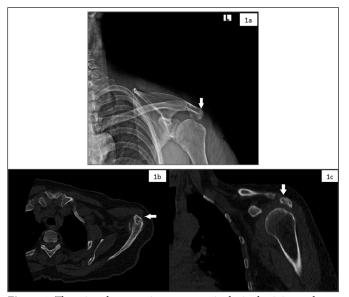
There is a degeneration on acromioclavicular joint and irregular appearance at the posteromedial edge of acromion on Zanca radiograph of the left shoulder (1a). Axial (1b), coronal (1c) CT images showed a central localized cystic formation which has sclerotic edges and calsifications on left acromion.
